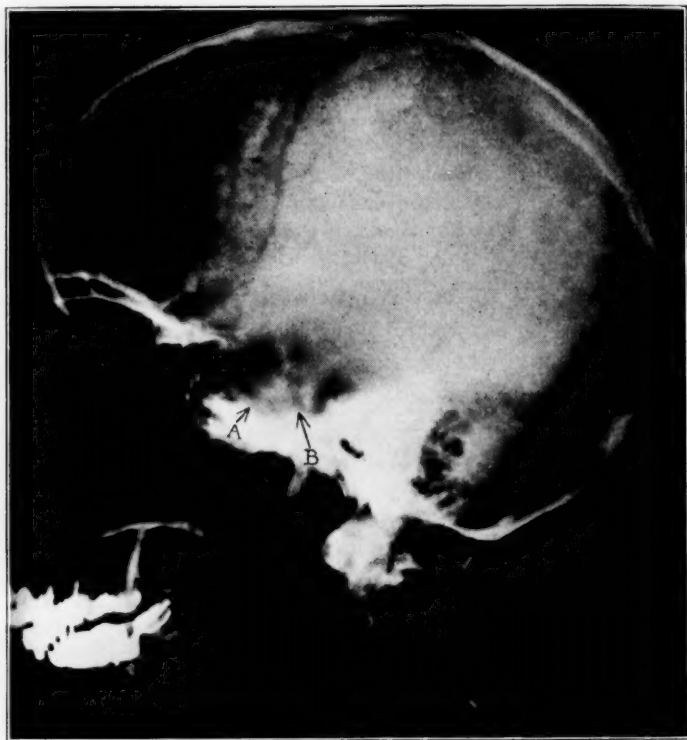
A roentgenogram of the cranium and cervical portion of the spine five years after operation in case 1 reported by Bailey and Bagdasar; before operation the osseous changes were scarcely detectable. The arrow (*A*) is directed toward the floor of the expanded hypophyseal fossa and (*B*) toward the clivus. Both areas show the destruction of bone. Compare this film with that of figure 2.
